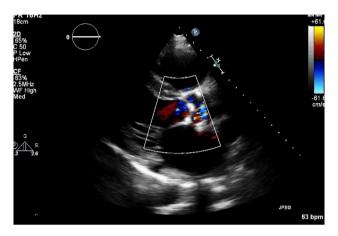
Echocardiography in long-axis parasternal view showing thickened and calcified aortic valve with significantly limited opening.
